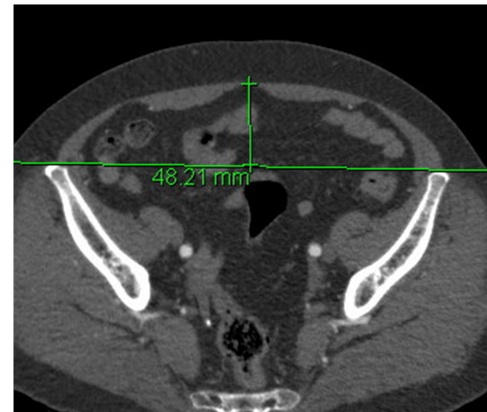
(Left) The table presents the Samsung Medical Center Risk Score for bulge/hernia, which is incorporated into the volumetry sheet. (Right) Abdominal wall protrusion is measured as the maximum vertical distance from a line connecting both anterior superior iliac spines to the inner border of the abdominal wall on preoperative CTA images. CTA: Computed tomography angiography.
